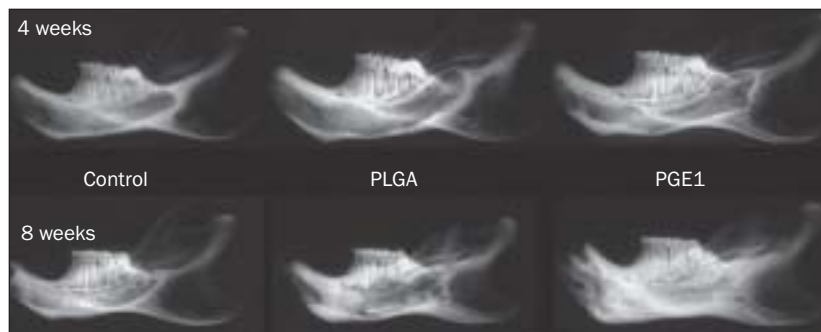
Soft radiographs of the mandibles at 4 and 8 weeks.
